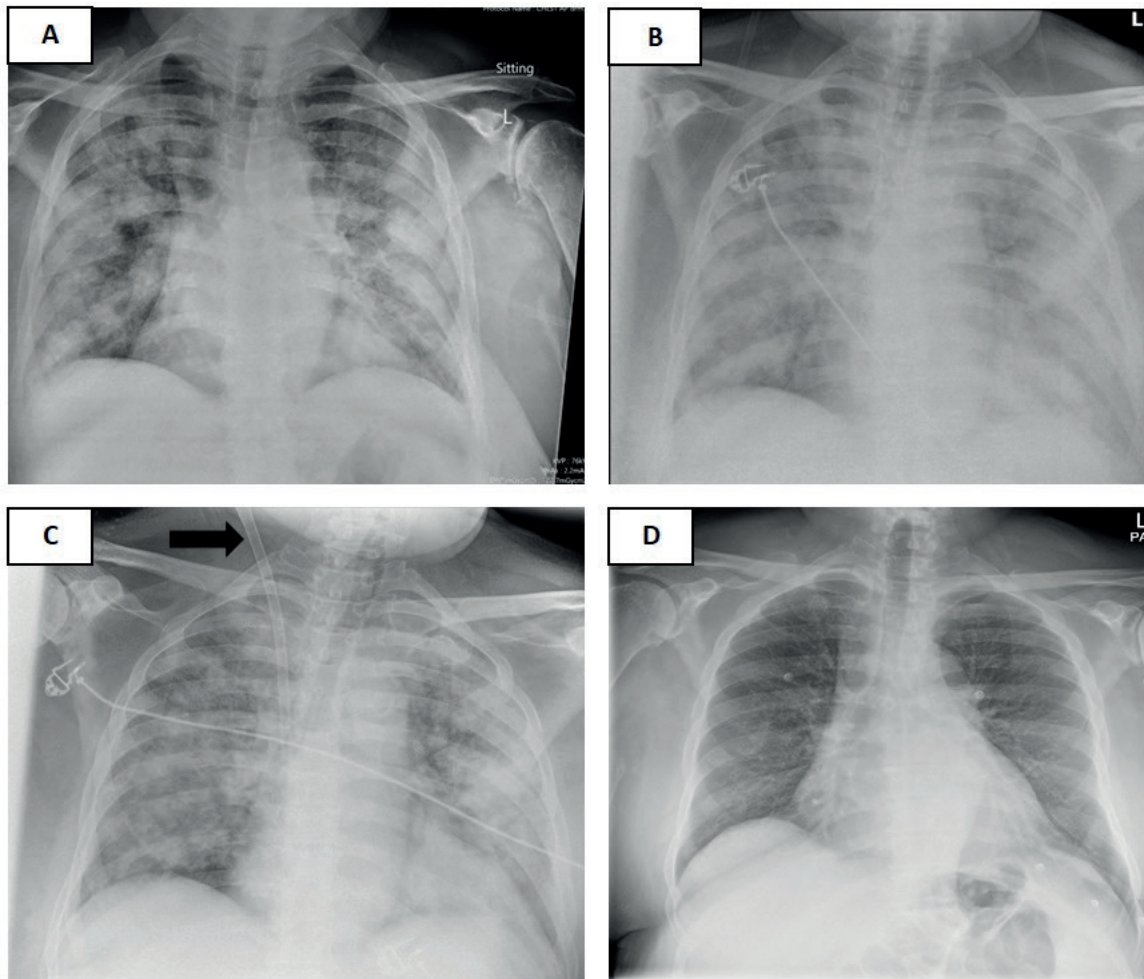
Posterior-Anterior (PA) chest X-ray showing bilateral lung opacities compatible with acute respiratory distress syndrome (ARDS), on patient's admission to the COVID-19 ward (A) severe ARDS with bilateral lung infiltrates on patient transfer to the intensive care unit (ICU) (B) after awake veno-venous extracorporeal membrane oxygenation (VV-ECMO) right jugular cannula insertion in the ICU (black arrow) (C) complete resolution of ARDS on discharge (D).
